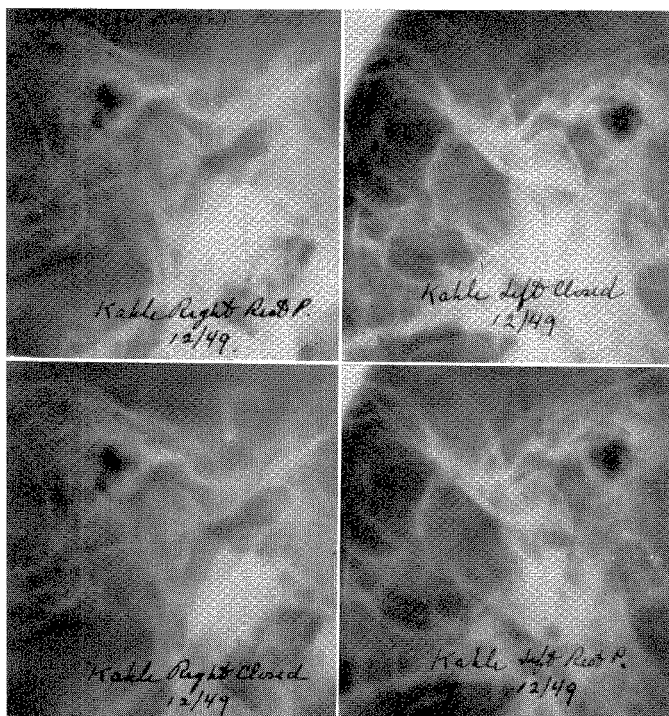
Roentgenograms of the temporomandibular joints taken in December, 1949.
